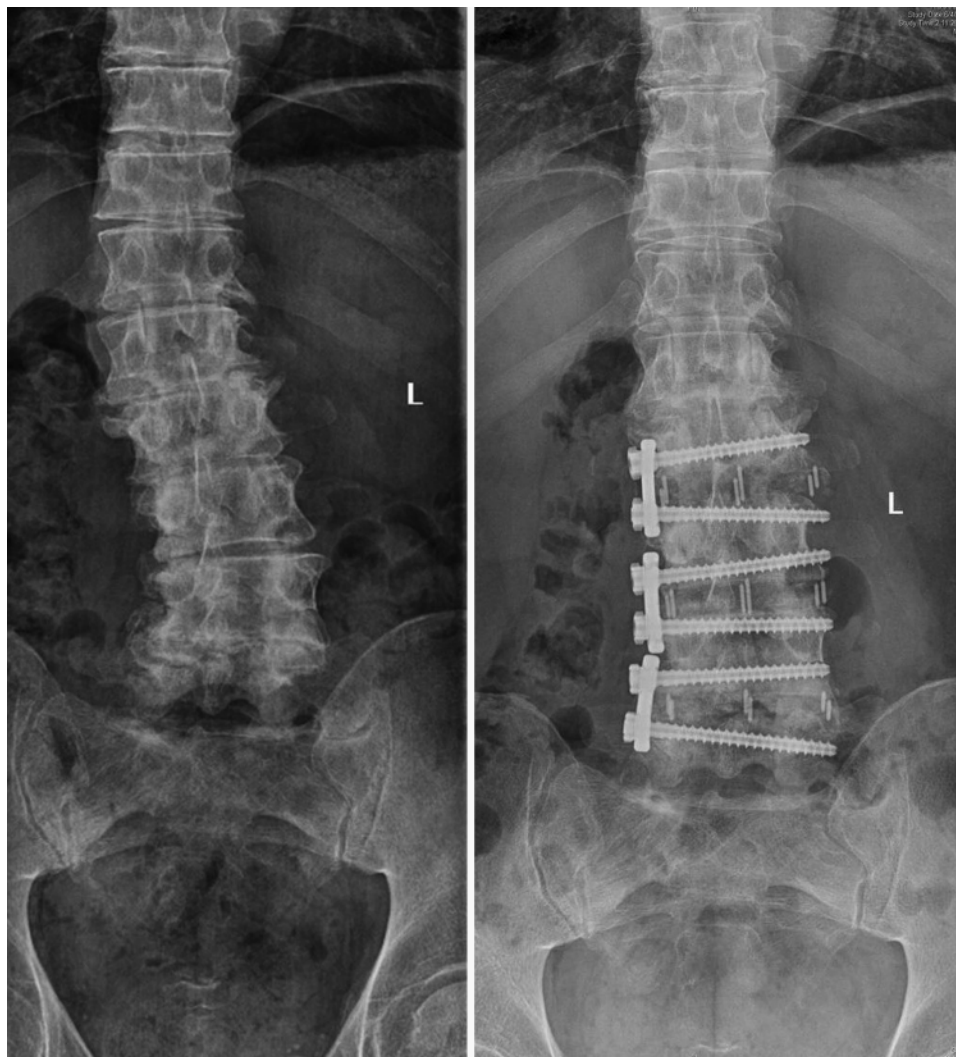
Preoperative (left) and postoperative (right) standing radiographs obtained in a patient who underwent a 3-level lateral transposas lumbar interbody fusion with lateral plate fixation.
